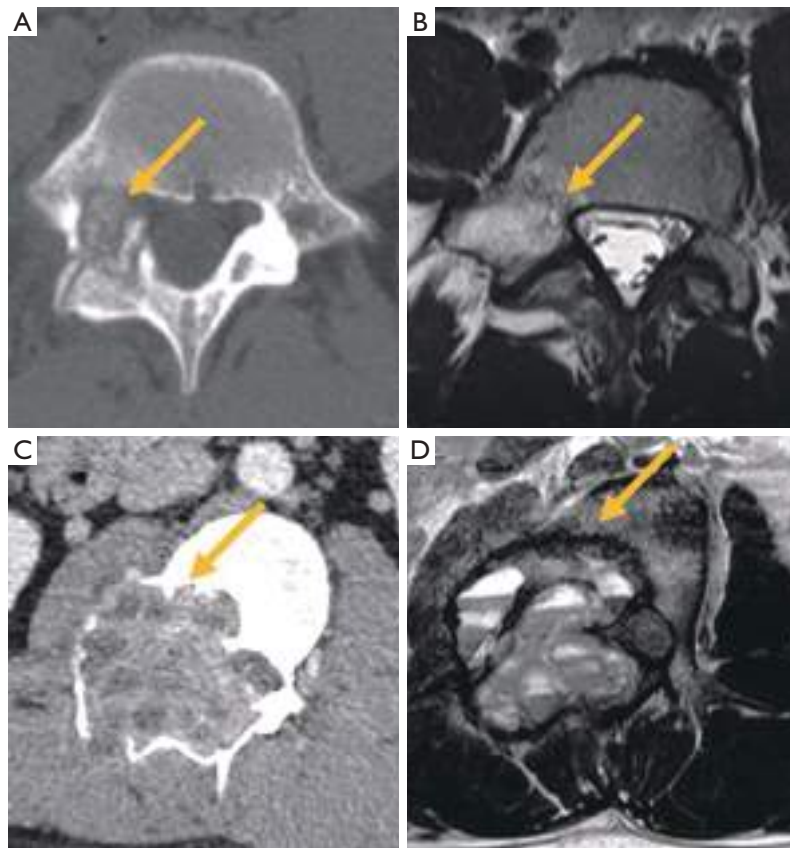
Osteolytic lesions of the spine. (A) Axial CT image of osteoblastoma showing the osteolytic lesion (arrow), and (B) edema pattern on MRI (arrow). (C) CT of aneurysmal bone cyst (arrow). (D) T2 weighted image showing fluid-fluid levels in the same case (arrow). CT, computed tomography; MRI, magnetic resonance imaging.
